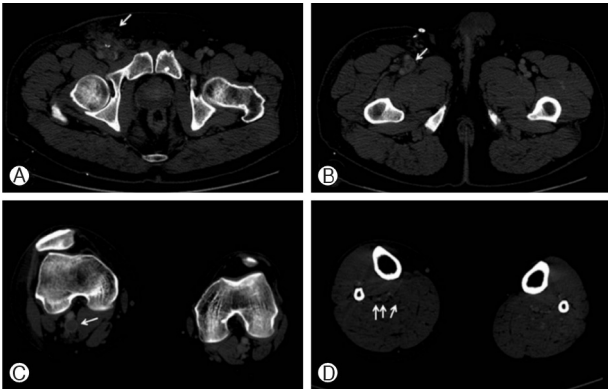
CT obtained six days after the hematoma evacuation. (A) Remaining, multiple, small hematomas with indistinct delineation around the right common femoral vein (arrow). (B) Venous thrombosis in the femoral vein (arrow). (C) Venous thrombosis in the popliteal vein (arrow). (D) Venous thrombosis in the calf veins (arrows).
